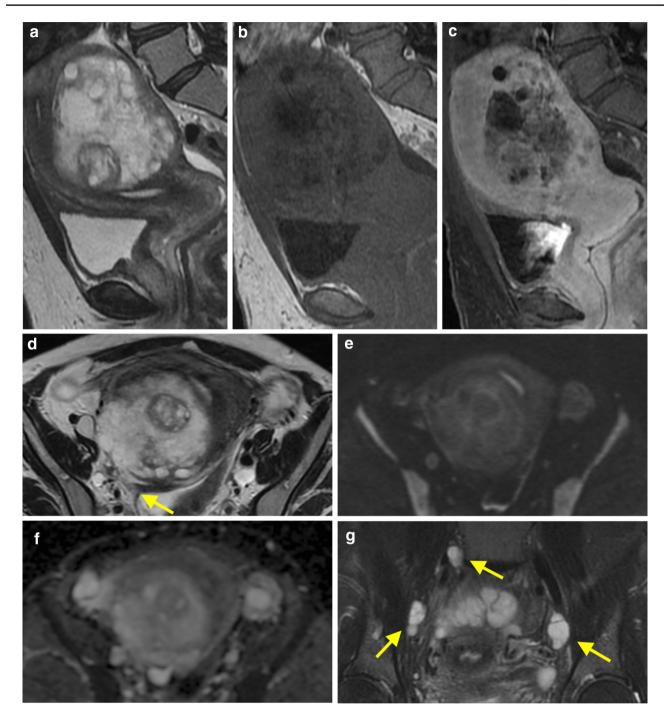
Contrast-enhanced MRI. a Sagittal T2WI, b sagittal T1WI, c sagittal post-contrast fat-saturated T1WI, d axial T2WI, e axial DWI (b=1000), f axial ADC map, g coronal fat-saturated T2WI. MRI showed aggregated cystic mass located in the uterine posterior wall. The mass showed high intensity on T2WI and mix intensity of low and intermediate on T1WI. The septa showed isointensity on T1WI
